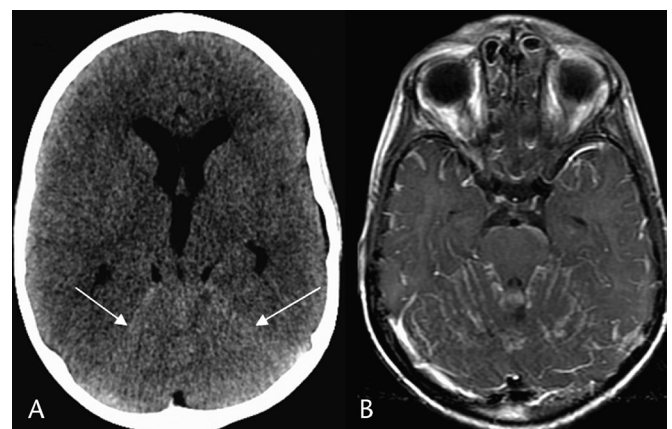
Medulloblastoma seeding with HC. Noncontrast CT (A) shows ventriculomegaly and accentuated high densities within the posterior fossa and along the tentorium (white arrows). Axial gadolinium T1 image (B) shows extensive leptomeningeal enhancement (seeding confirmed by lumbar puncture).
